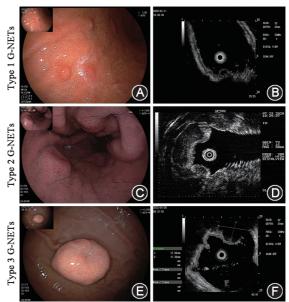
Endoscopic features of patients with different clinical types of G-NET. (A) Gastroscopic view of multiple polypoid lesions of 5 mm in diameter. (B) Endoscopic ultrasonography of a hypoechoic lesion limited to the submucosa in the gastric body. (C) Gastroscopy showed multiple polypoid elevations on the thick gastric body folds. (D) Endoscopic ultrasonography showed that the lesion was limited to the submucosa. (E) Endoscopic examination of a solitary lesion of 2.5 cm in diameter located in the gastric body. (F) Ultrasonographic endoscopic visualization of a lesion invading the muscularis propria. G-NET: Gastric neuroendocrine tumors.
